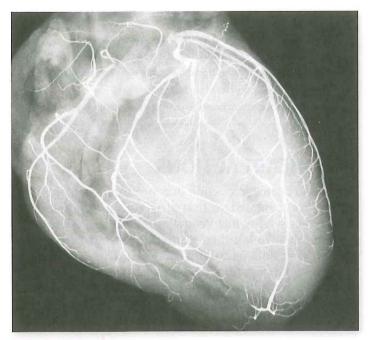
An angiogram (radiograph) of the coronary arteries is a diagnostic procedure used to examine specific blood vessels.
